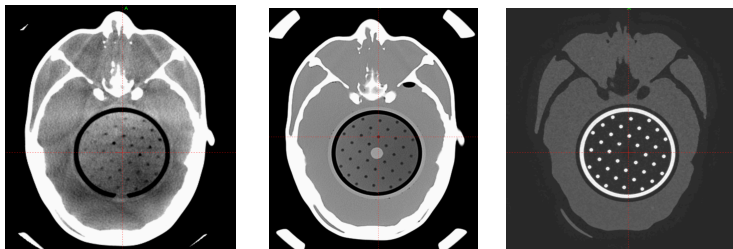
CBCT scan on left, Diagnostic CT in middle, MR scan on right, demonstrating difficulties visualising the internal structure of the MR insert with CBCT
